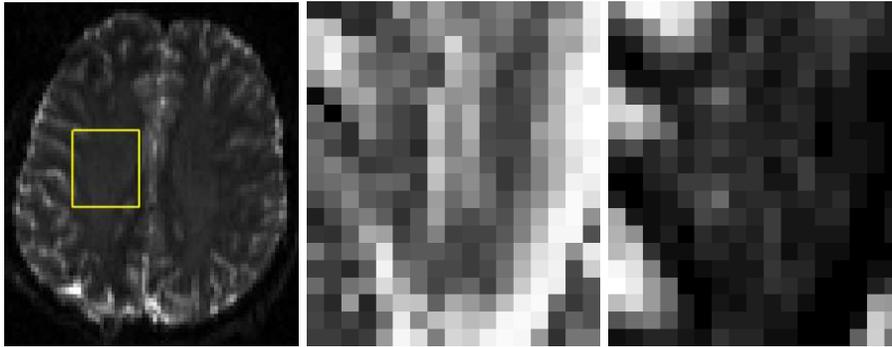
This figure shows the T2 weighted MRI of a normal human subject derived from the non-difision sensitized HARDI gradient images. The region over which the patient data was extracted is marked in yellow, with its GFA and EI plots shown in the middle and right panels respectively. Visually, we notice that the EI plot nicely separates gray matter from white matter. Unlike GFA, gray matter has greater EI values than white matter.
